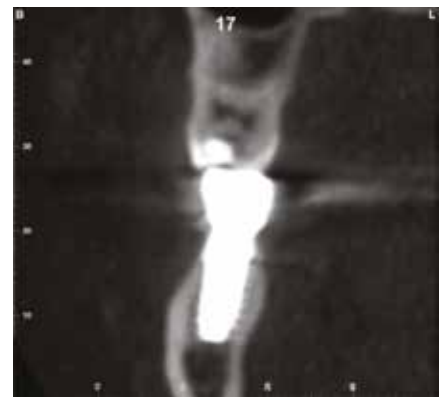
CBCT cross section before treatment demonstrating bone level on buccal/lingual side of the implant and the density of the cancellous bone in contact with it.
